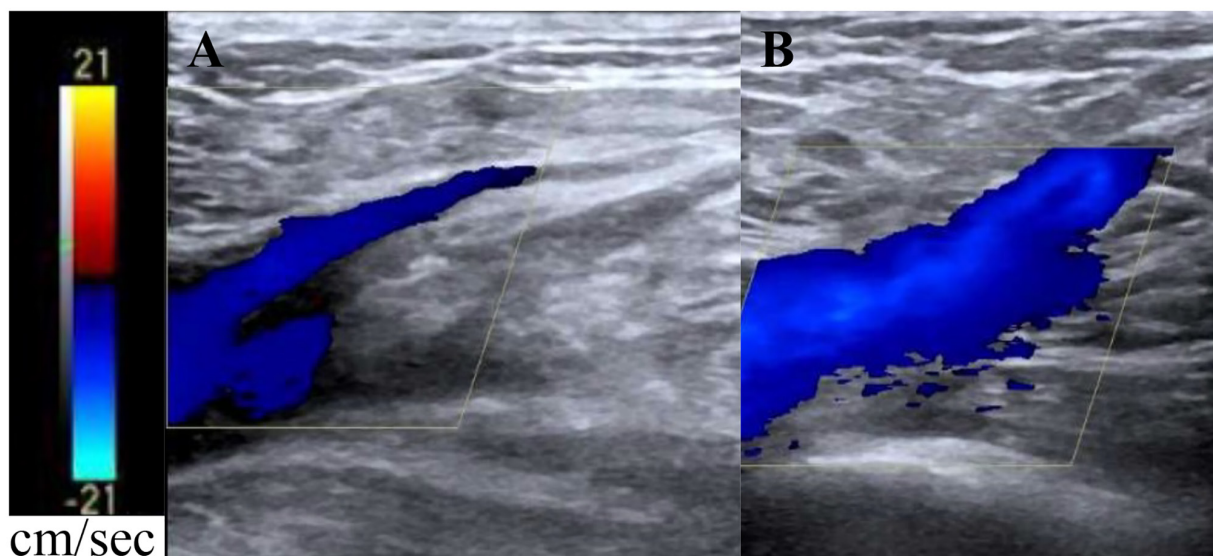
Color Doppler ultrasound of lower limb veins of the patient 10 day after the surgery. (A) Image of the inflow segment of the great saphenous vein into the femoral vein when the patient held his breath. (B) Image of the inflow segment of the great saphenous vein into the femoral vein when the patient was breathing normally. The blood flow in the vascular lumen of lower limbs of the patient was unobstructed and there was no obvious embolism.
